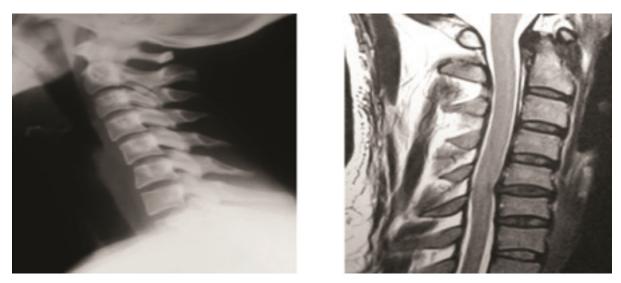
Pre-operative X ray lateral view and MRI sagittal view showing CSM at C_5 - C_6
